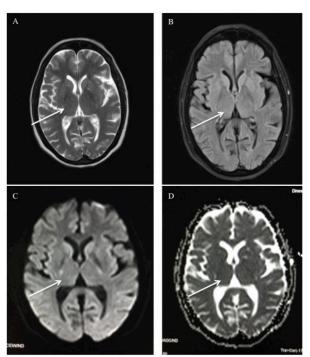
A-D: MRI of brain T2, Flair, DWI and ADC shows normal study.
